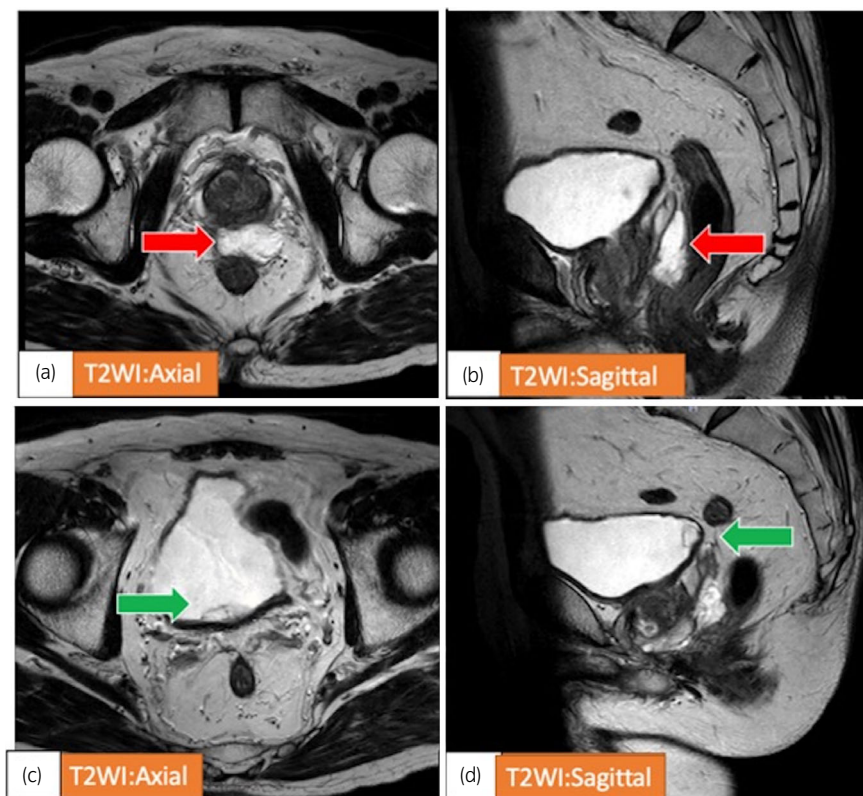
MRI was performed 2 weeks after insertion of the SpaceOAR[®] Hydrogel. (a, b) Red arrow shows the hydrogel in the correct space between the prostate and the rectum. (c, d) Green arrow shows the hydrogel in the bladder.
